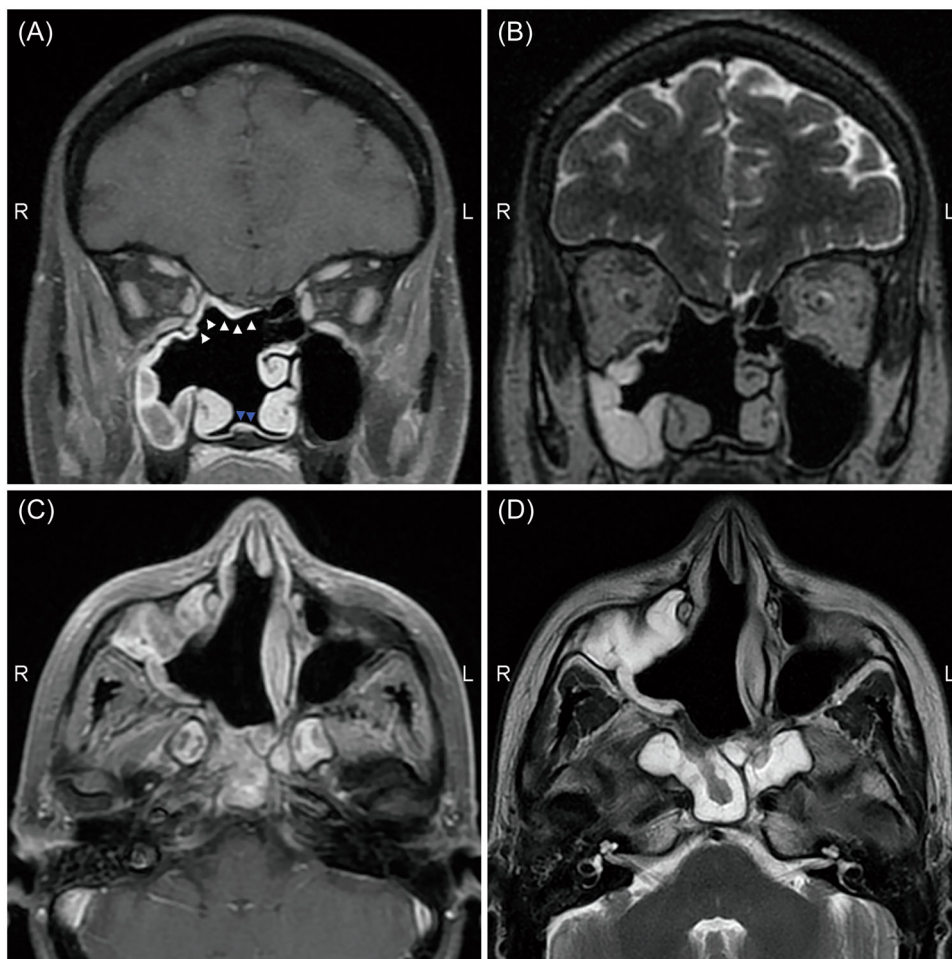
Postoperative contrast-enhanced T1-weighted and T2-weighted magnetic resonance imaging in coronal (A, C) and axial (B, D) view, performed 6 months after multimodal treatments, showed complete tumor removal without recurrence of disease. White arrows mark the septal flip flap of the anterior cranial fossa reconstruction; blue arrows mark the reverse septal flap.
